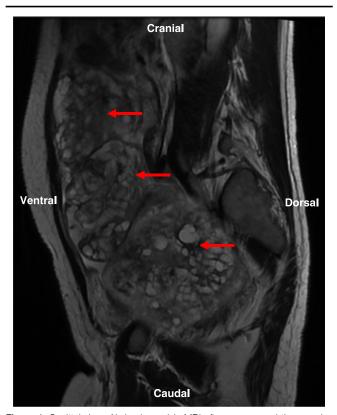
Sagittal view. Abdomino-pelvic MRI after surgery and three cycles Bleomycin-Etoposide-Cisplatin chemotherapy showing significant disease progression including an 11.3 cm porta hepatis mass, a 9.2 cm mass overlying liver segments 6 and 7, a 5.3 cm right subdiaphragmatic mass and a 16 cm pelvic mass (red arrows).
